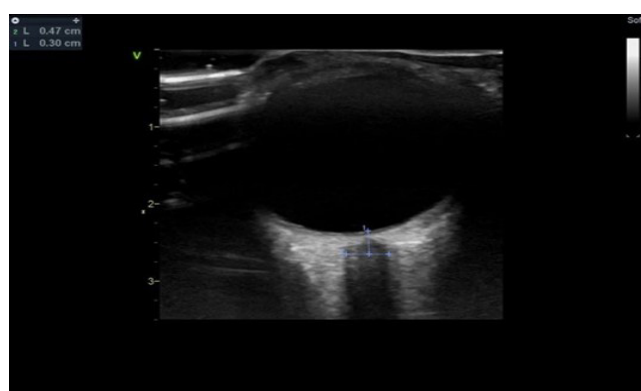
Measurement of optic nerve sheath diameter by ultrasound.
